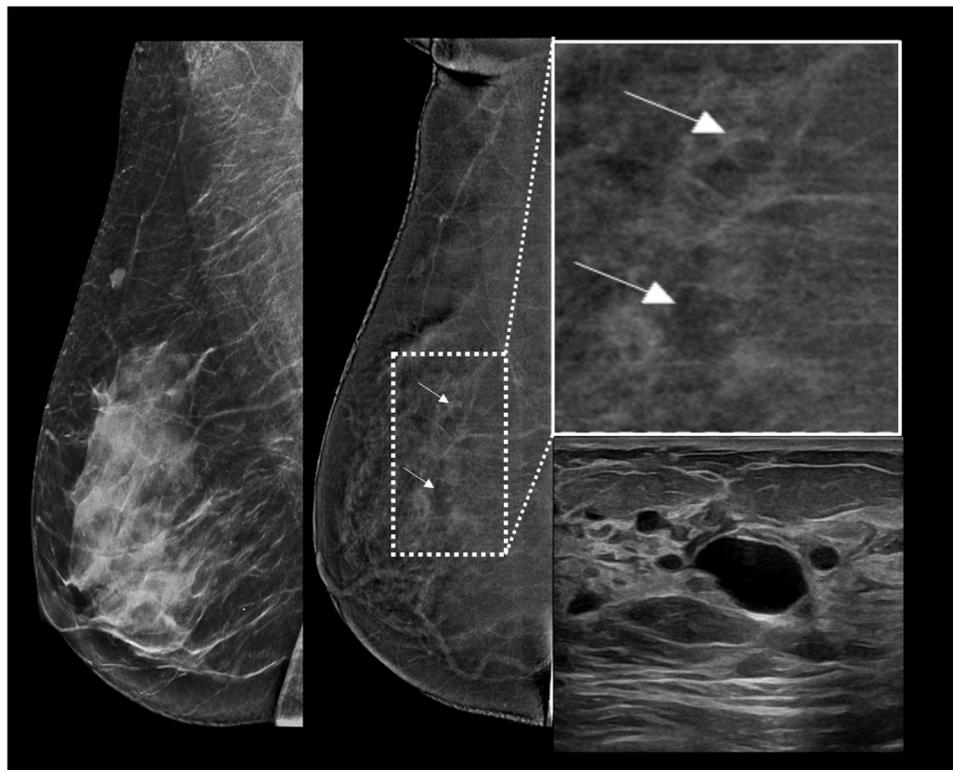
Negative contrast enhancement/ Eclipse sign; Negative contrast enhancement in cysts, contrast enhanced mammography and ultrasound images in a 42-year-old woman who had presented with mastalgia and had positive family history for breast carcinoma. Medioloateral oblique view, low energy image (left) of the right breast reveals heterogeneously dense breast; recombined image and digitally zoomed image (right) show negative enhancement due to cysts seen as low-density areas (white arrows); correlative ultrasound image (lower right corner) depicting multiple thin-walled anechoic cysts scattered in the breast parenchyma.
